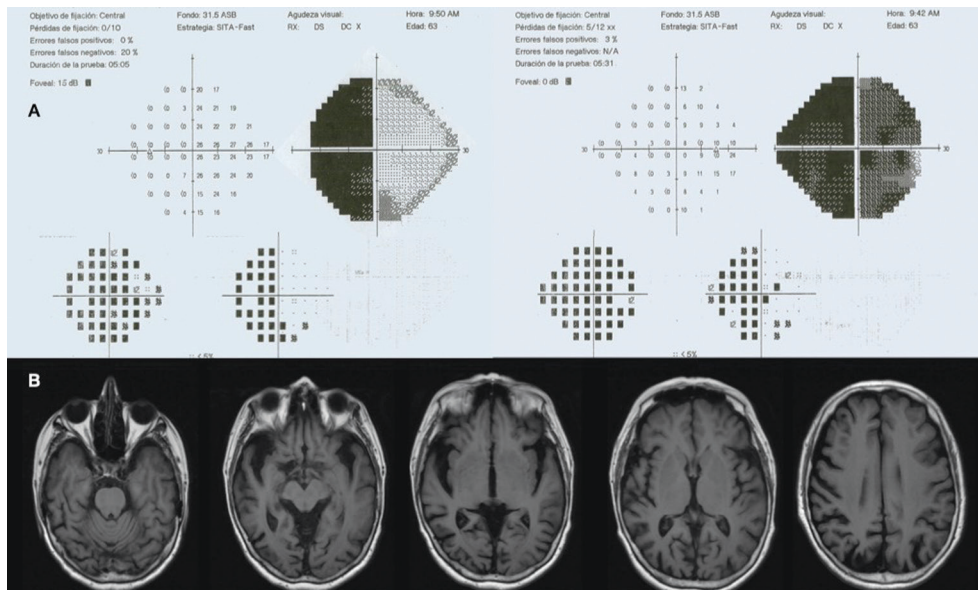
Patient's tests performed 4y prior A: First visual fields, this visual field was taken into consideration for the diagnosis of normal-tension glaucoma. Although not reliable, the pattern deviation map in the left eye clearly shows a temporal hemianopia, which appears to be homonymous when analyzing both eyes; B: First magnetic resonance imaging. No structural lesions were reported at the time, which could explain a possible homonymous hemianopia.
